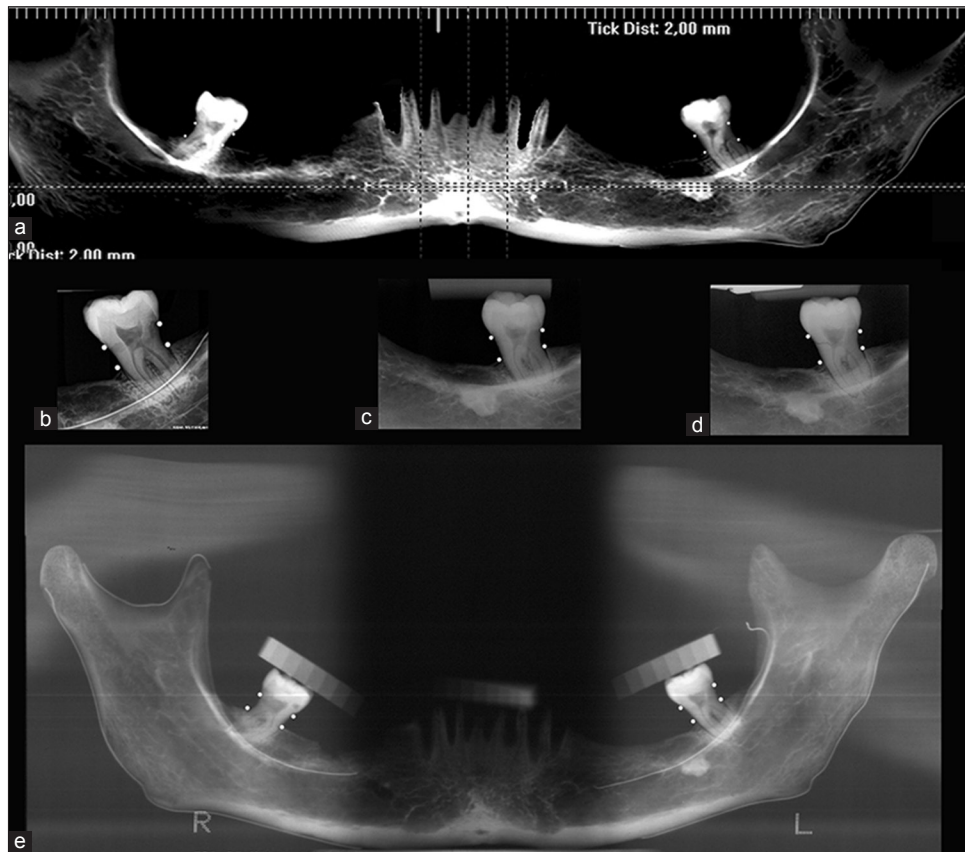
(a) Cone-beam computed tomography image. (b) Digital periapical radiography with complementary metal-oxide semiconductor sensor. (c) Conventional periapical radiography with film holders Han-Shin. (d) Conventional periapical radiography with film holders Rinn XCP. (e) Panoramic radiography
